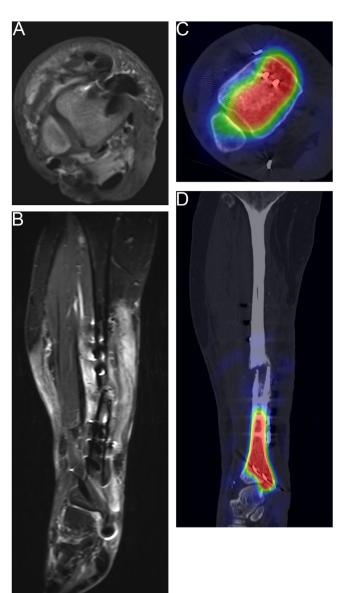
Superiority of ^{99m}Tc-antigranulocyte SPECT/CT compared to MRI in a patient with osteosynthesis-related infection.
